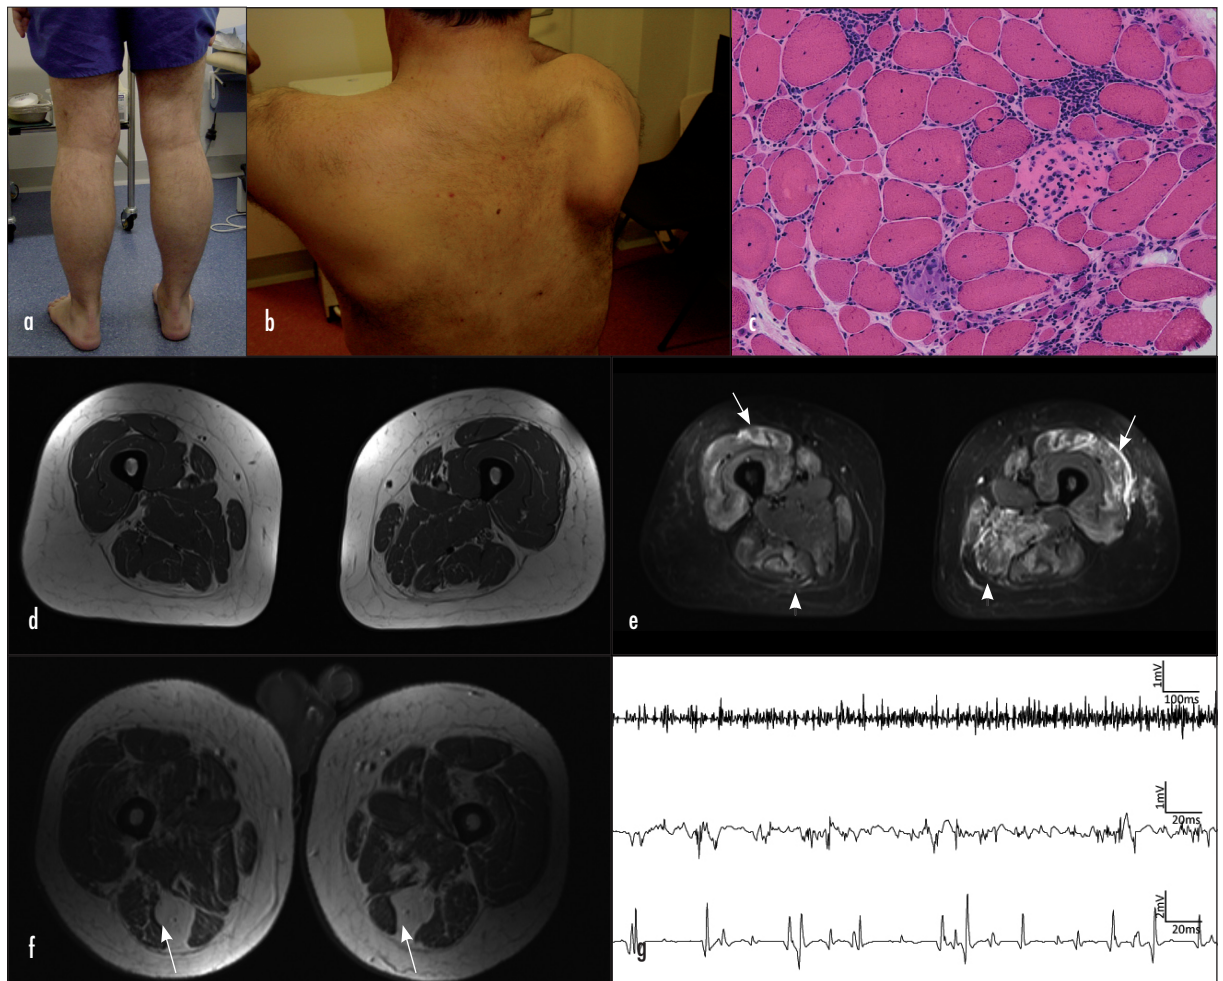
Diagnostic approach to muscle disease. Clinical features such as (a) calf hypertrophy or (b) scapular winging can narrow the differential diagnosis. c. Muscle biopsy showing focal endomysial inflammation, a pale necrotic fibre and a basophilic regenerating fibre, marked variation in fibre size, and increased internalized myonuclei suggestive of an inflammatory myositis. Non-invasive techniques such as muscle magnetic resonance imaging are increasingly used. d. Axial magnetic resonance imaging of the thighs showing normal muscle bulk on T1-weighted images but (e) high signal indicating oedema affecting the quadriceps (arrows) and hamstring muscles (arrowheads) on T2-weighted images with fat suppression in a case of myositis with anti-SRP antibodies. f. Complete fatty replacement of the semitendinosus muscles (arrows) in titinopathy as an example of selective muscle involvement detectable on magnetic resonance imaging. g. Three electromyography traces showing myopathic early full recruitment (top row), low amplitude short duration polyphasic myopathic motor units (middle) and normal motor units (bottom) for comparison.
